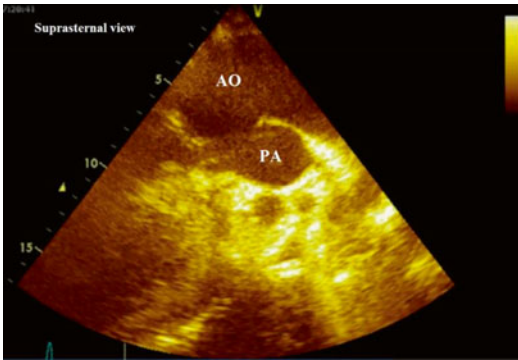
Aortopulmonary septal defect in transthoracic echocardiography in suprasternal view (Video 52.2). AO aorta, PA Pulmonary artery
